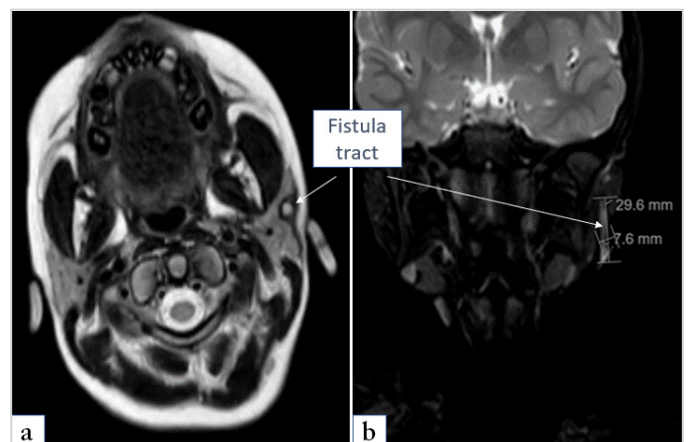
a, b) MRI T2 axial and coronal sections showing the fistula tract on the left side
